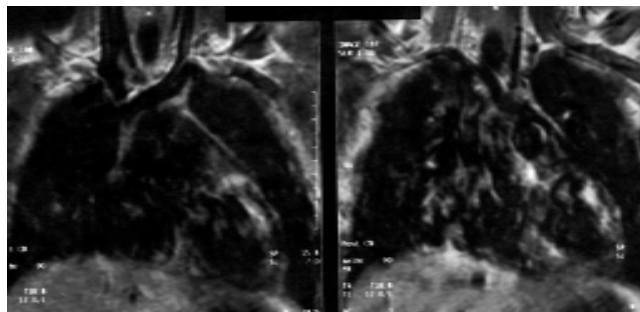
T1 weighted MR image shows thinning and high signal intensity of fat in the left ventricular wall.
